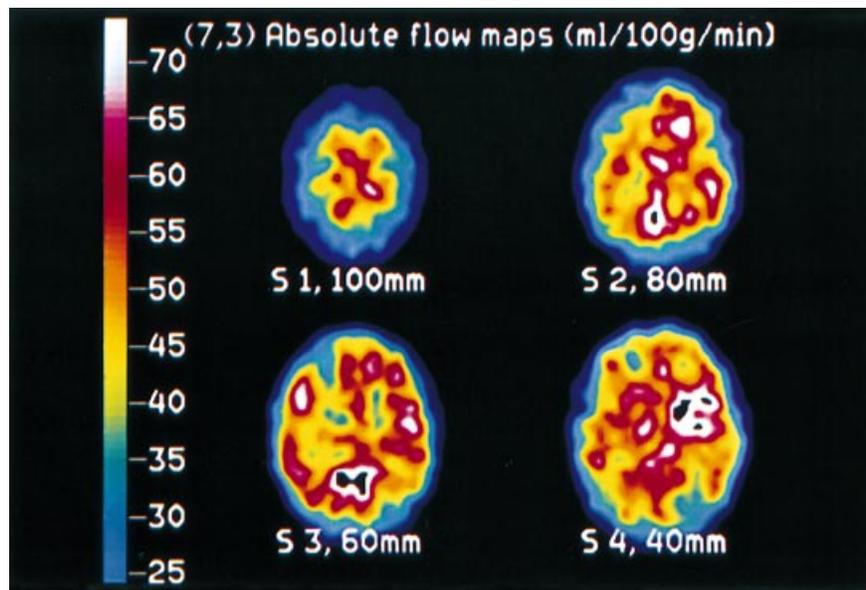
Interictal ^{133}Xe single photon emission computed tomography before left hemisphere disconnection. Absolute flow maps show hypoperfusion in the left hemisphere compared with the right hemisphere, more pronounced in frontal regions (left hemisphere is on the left, right hemisphere on the right).
